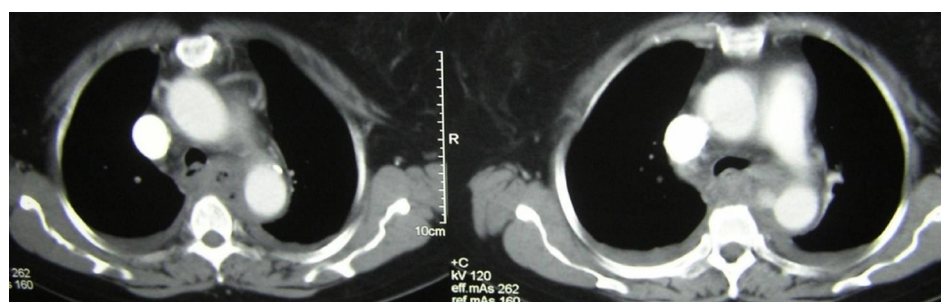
Axial cut of CT thorax on mediastinal window. Pseudoaneurysm (red arrowhead) at the proximal part of the descending aorta in the region of the abscess collection
